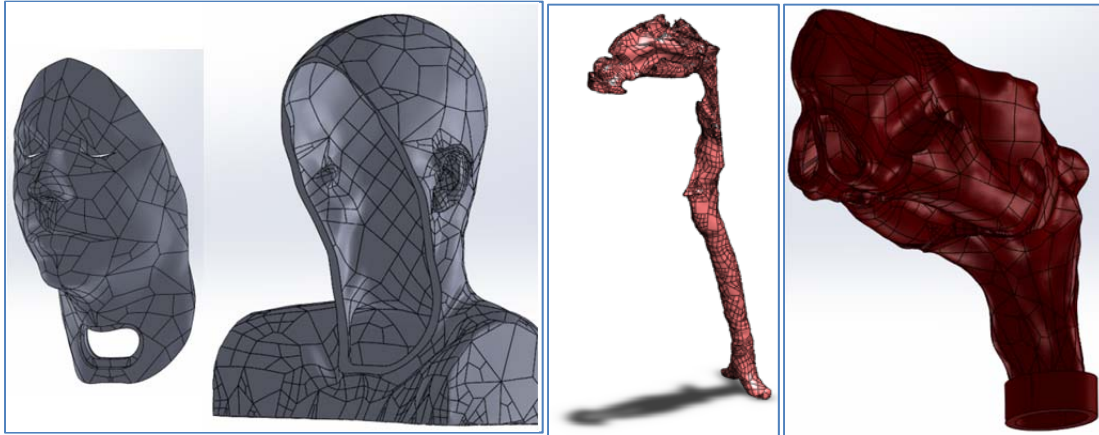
CT derived skin surfaces with substantially uniform offset, reduced thickness in the facial regions close to skull surface. “Negative space” of airway including nasal, pharyngeal and tracheal regions. Detail of simplified airway with continuous passages through left and right nostrils.
